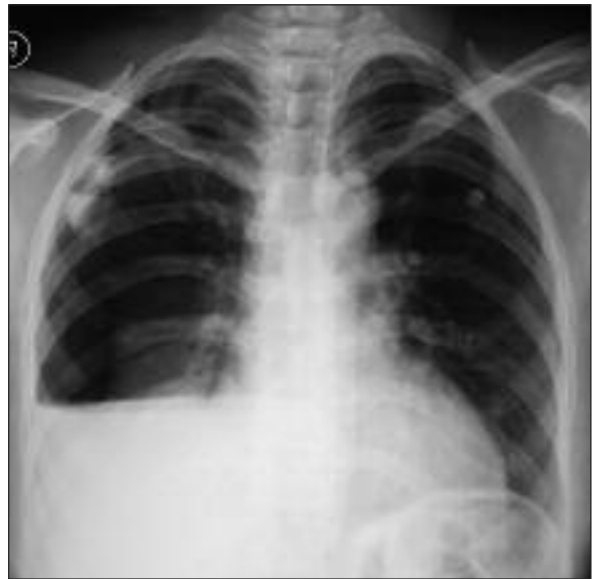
Chest X-ray, hemopneumothorax image on right hemithoracic image.
